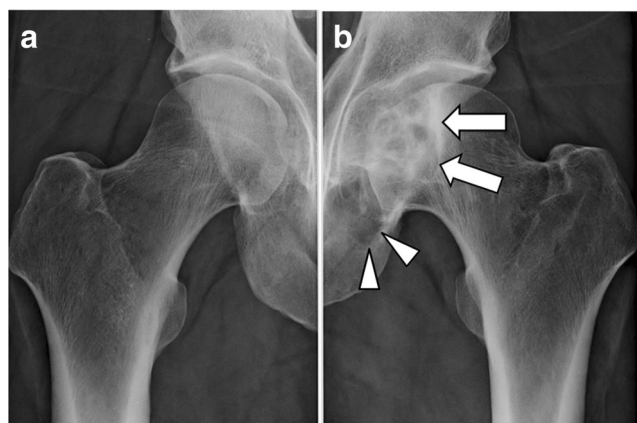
Radiographs of the hips show a the normal appearance of the right proximal femur, and b osteolytic foci surrounded by sclerosis in the left femoral head (*arrows*) and ilio-ischiatic branch (*arrowheads*). Note dysmorphism of the left proximal femur, with a hypoplastic femoral head, and an enlarged and shortened femoral neck
